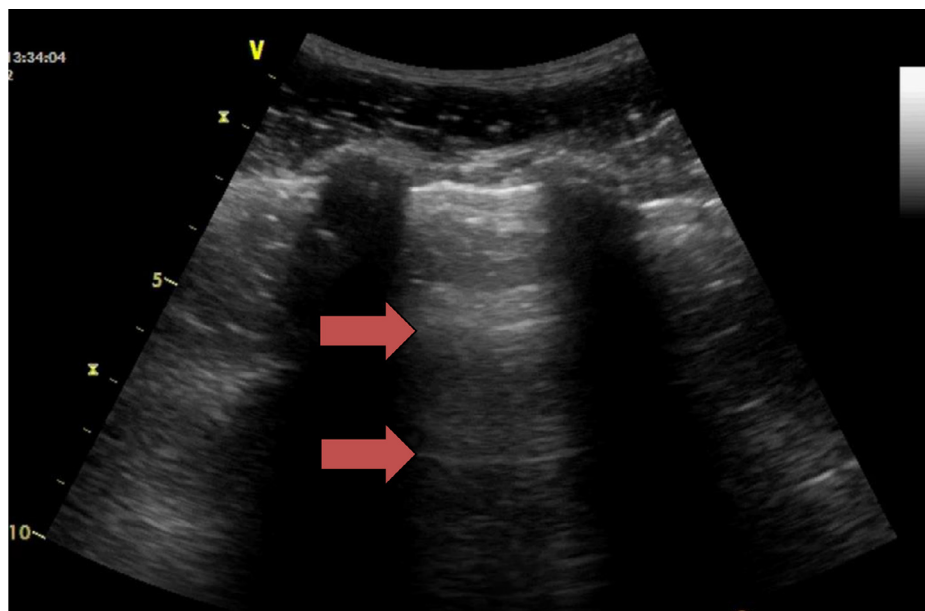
Normal aerated lung ultrasound showing the horizontal reverberation artifacts (A-lines) of the pleural line (red arrows). The characteristic appearance of two ribs and the pleural line in between is often referred to the “bat sign.”
